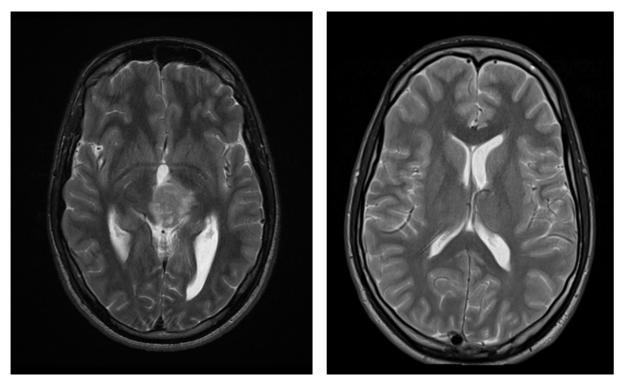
Brain MRI with contrast showed a heterogeneous, irregular-shaped central mass with marked enhancement in the pineal region (left). Repeat imaging following radiotherapy showed significant interval regression (right).
